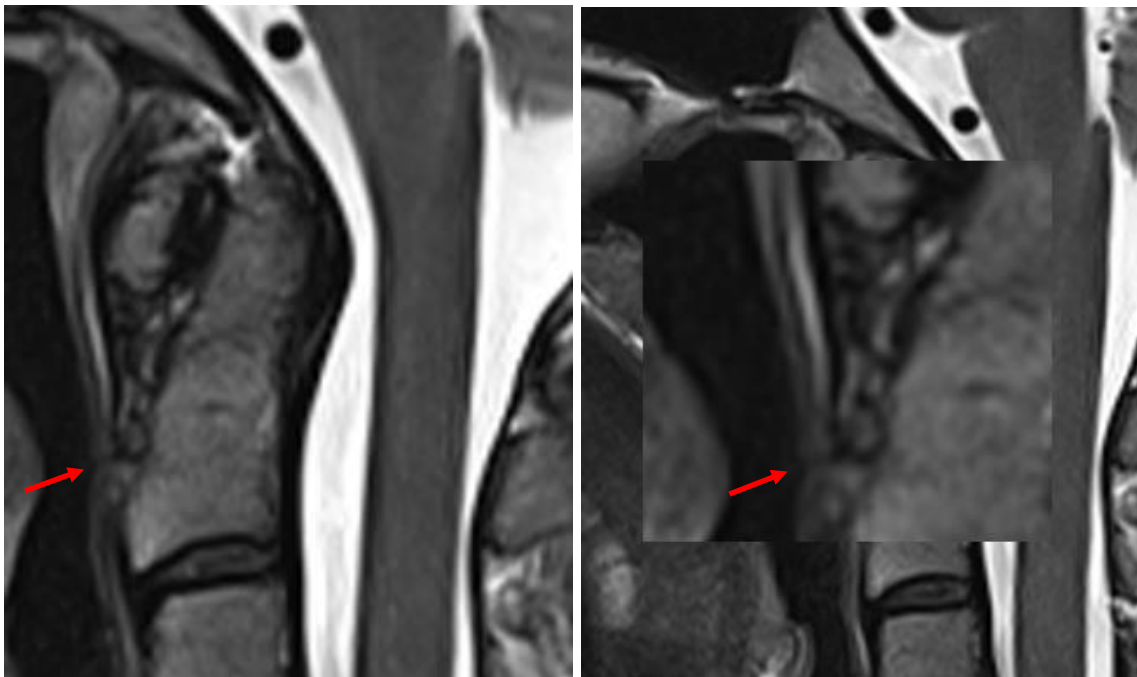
3T MRI, T2-weighted sagittal TSE at the level of the upper part of the dens axis-atlas. The right picture with enlargement of the pathological findings.
